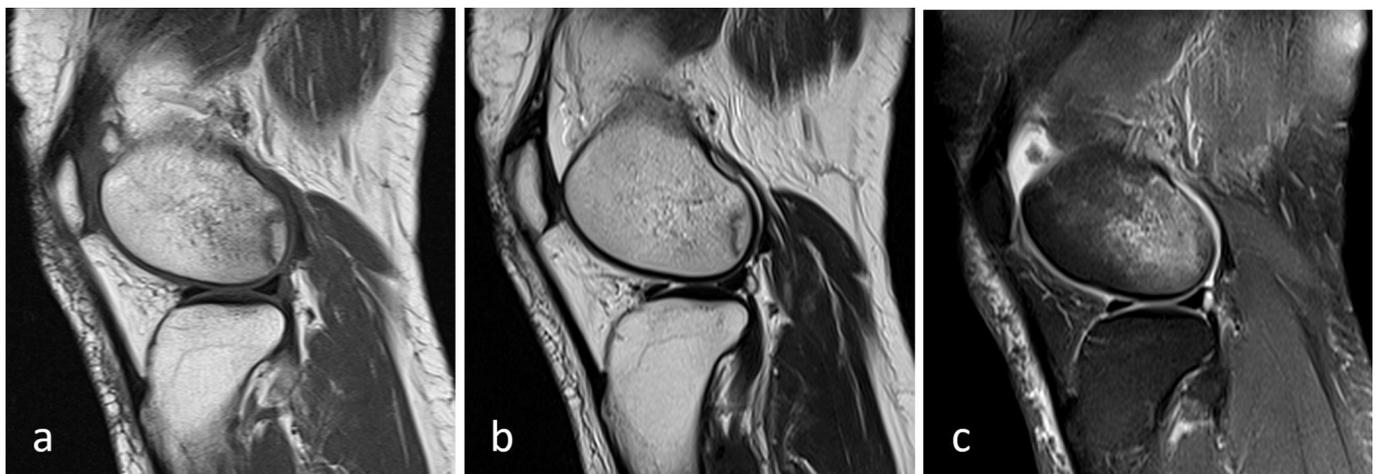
Sagittal T1- (a), T2- (b) and proton density-weighted MRI with fat saturation (c) showing insufficiency fracture in posterior non-weight-bearing zone of lateral femoral condyle with extensive marrow edema in a 50-year-old female.
